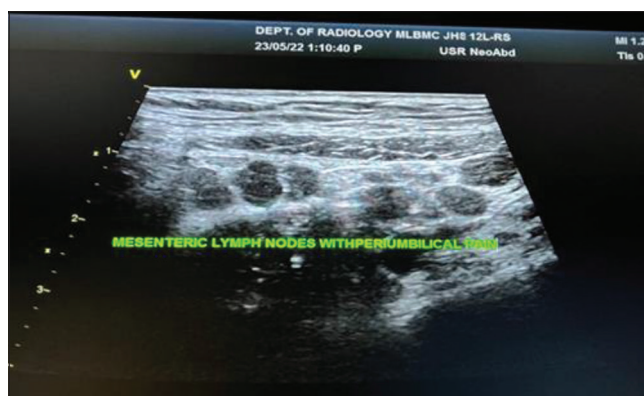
Mesenteric lymphadenitis: High-resolution ultrasound image showing multiple variables sized enlarged mesenteric lymph nodes
